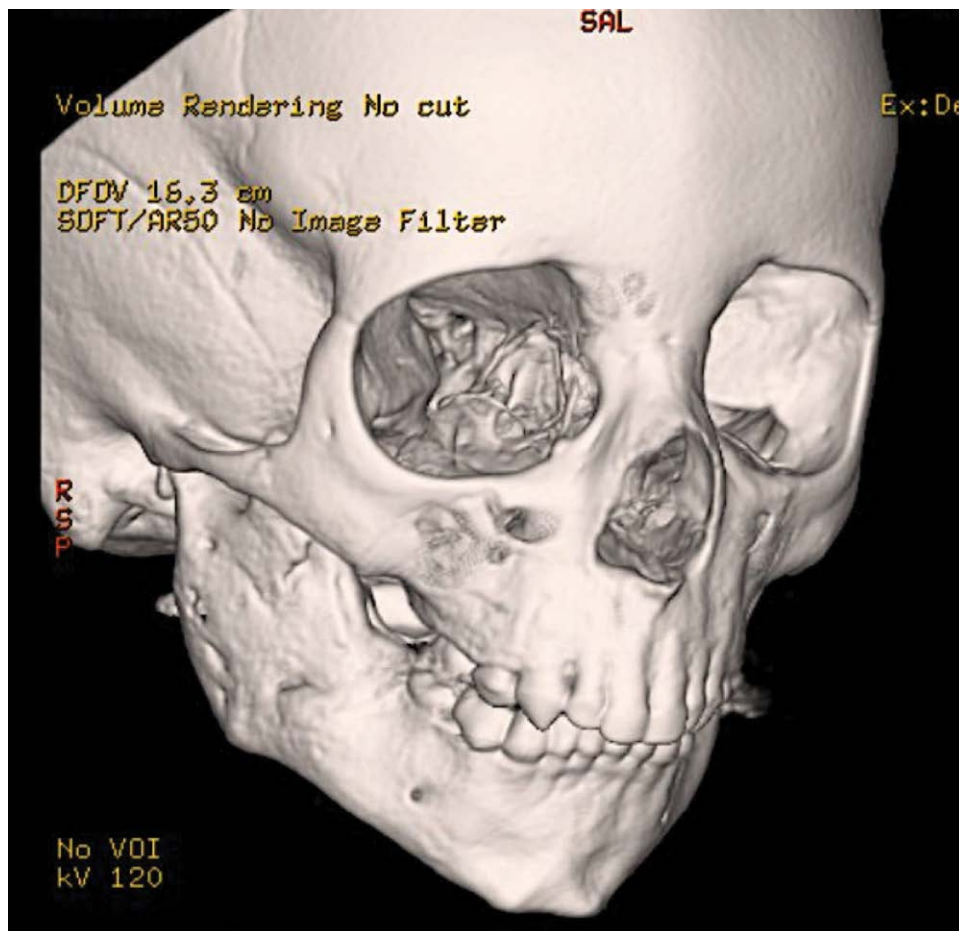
Postoperative cranio-maxillofacial three-dimensional computed tomography reconstruction of the lesion.
